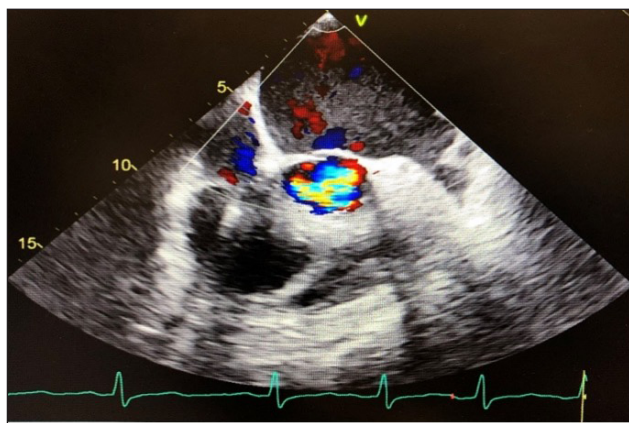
Post-COVID-19 transesophageal echocardiogram showing severe aortic regurgitation.
